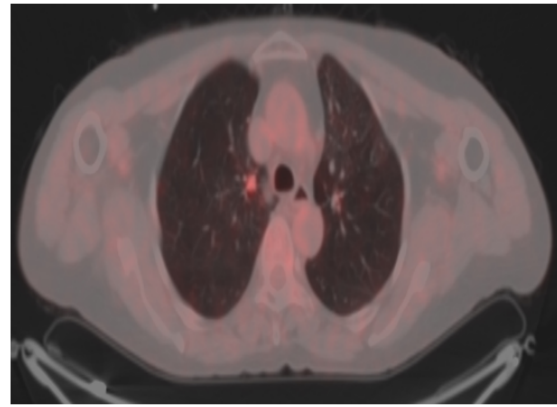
PET/CT revealing a 16 mm nodule with a 10.8 SUVmax at the right upper lobe apical segment.
